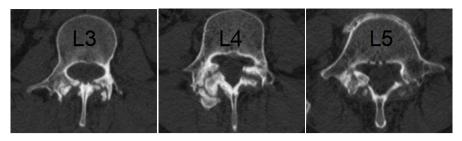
Preoperative computed tomography (CT) transversal reconstructions showed bilateral spondylolisthesis.
